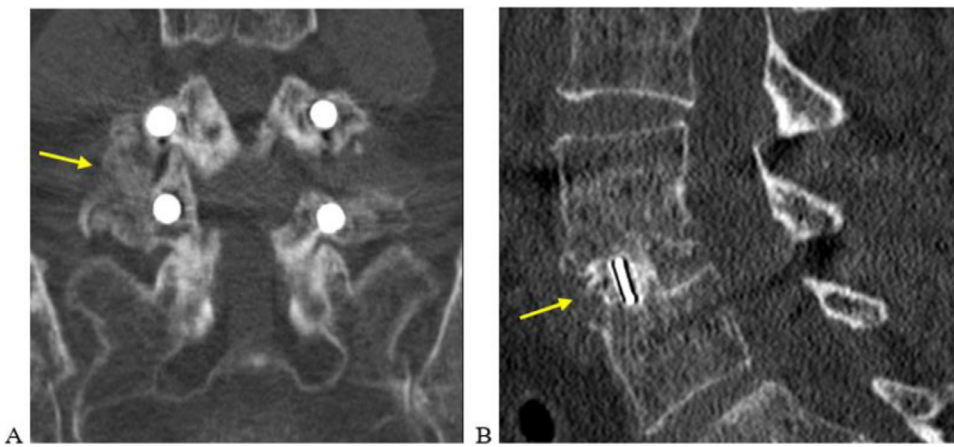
CT scan: (Left) Intertransverse graft on the opposite side to the transforaminal approach. (Right) Interbody graft.
